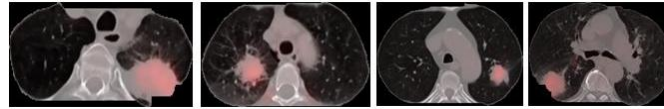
Four examples of fused thoracic PET-CT images (transaxial slices). The images depict tumors at different locations in the lung fields, and in two images showing the tumors adjacent to the chest wall and the mediastinum.
